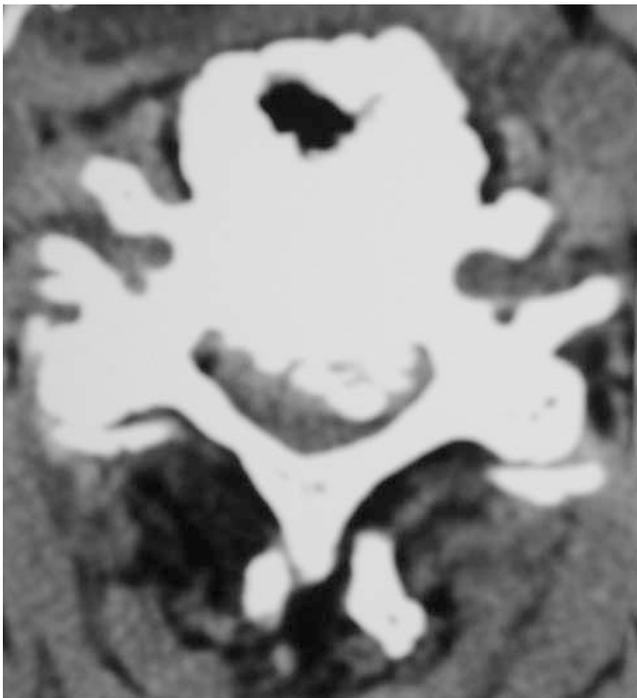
Transaxial noncontrast CT scan at the mid C6 vertebral level showing massive mature OPLL and early OPLL, characterized by pearls of ossification, contributing to marked ventral cord compression
